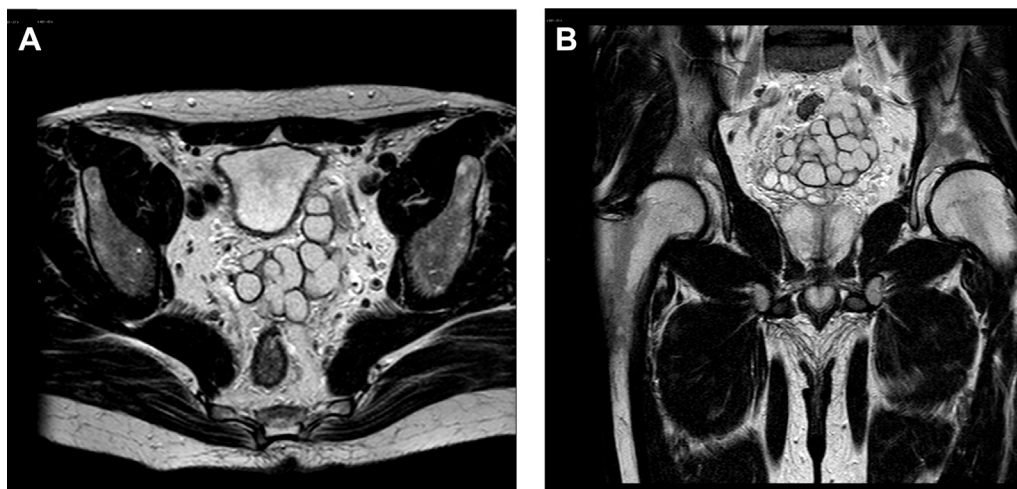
Axial MRI of the pelvic region (A), with coronal reconstructions (B) demonstrates a located cystic lesion in region of left seminal vesicle. The cystic lesion appeared bright on T2-weighted images.
